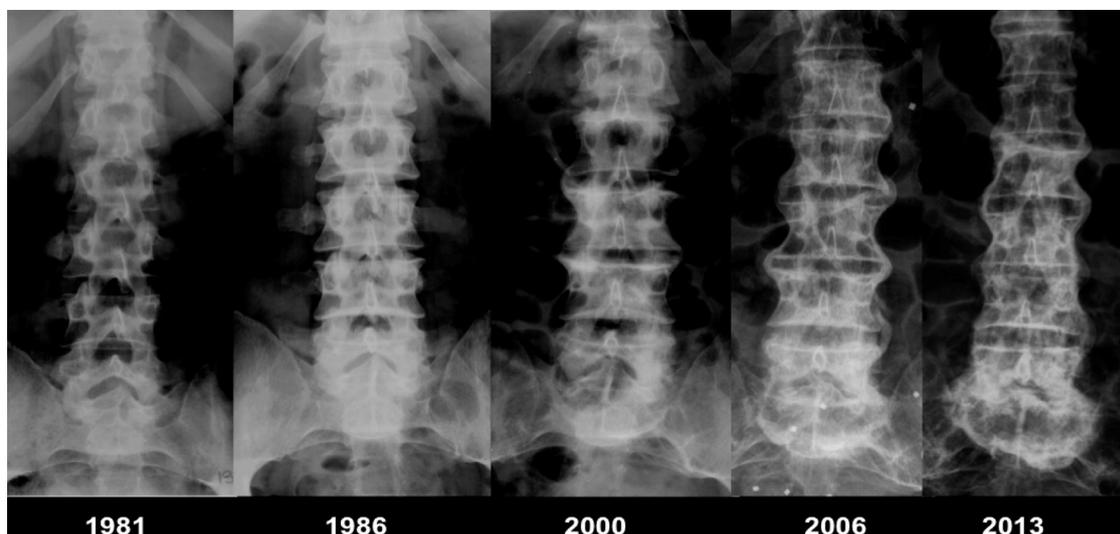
Radiographic evolution of diffuse idiopathic skeletal hyperostosis (DISH) and L5-S1 Charcot spine in a C7 tetraplegic patient (case 1).
